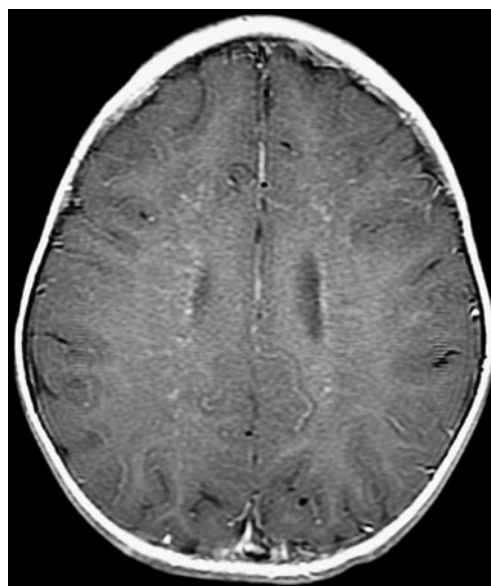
Axial T1-W post-gadolinium MR image demonstrates both punctate and linear enhancement of the deep white matter of both cerebral hemispheres and mild leptomeningeal enhancement
